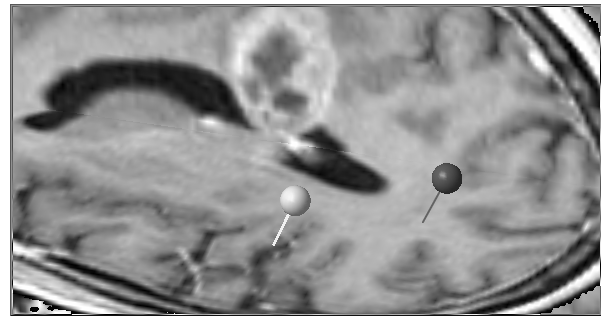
Two MEG dipoles overlaid onto the MRI.
